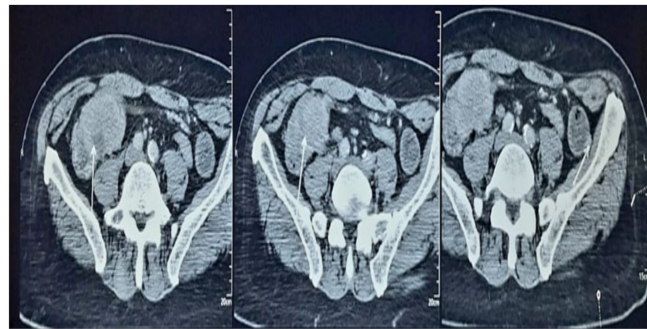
a CT scan slide showing the tumor (arrow)
